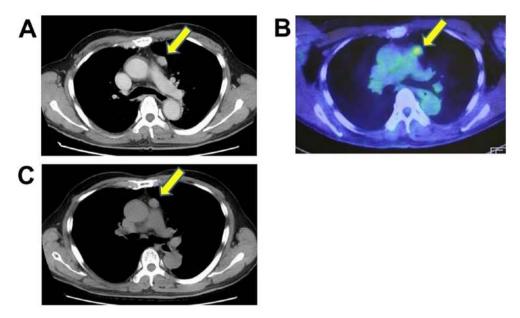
(A) CT scans performed during follow-up after lip surgery for SCC revealed a mass lesion in the mediastinum (arrow) 9 years after SCC diagnosis. (B) Subsequent FDG positron emission tomography/CT showed high FDG uptake by the mediastinal mass (standardized uptake value max=4.45: arrow). (C) A second CT performed 6 months later revealed mass growth (arrow). CT, computed tomography. SCC, squamous cell carcinoma. FDG, 2-[18F]-fluoro-2 -deoxy-D-glucose.
